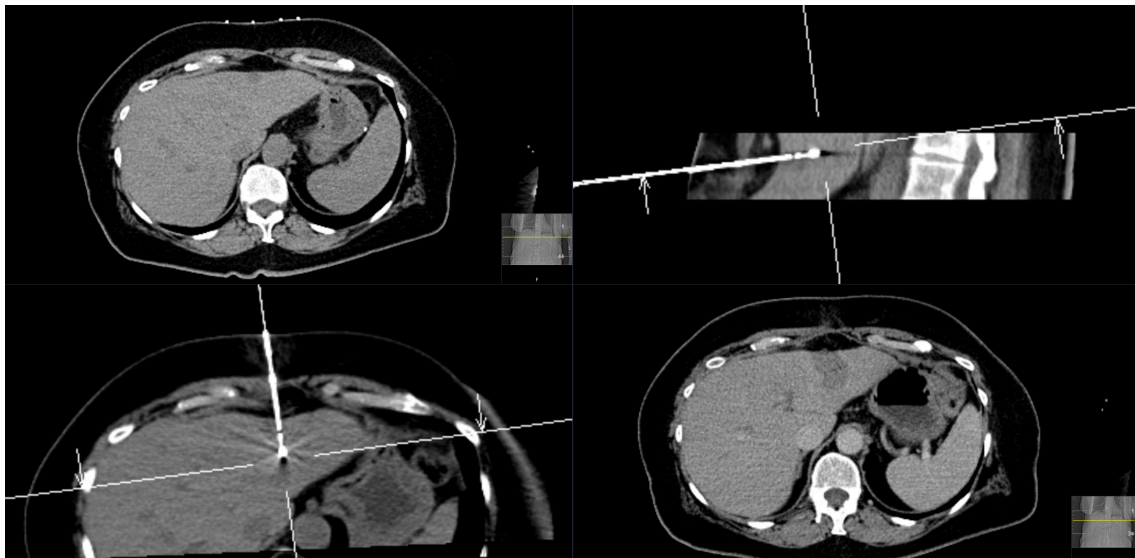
Planning and multiplanar CT-guided step-by-step positioning of a MW antenna in the liver segment III.
